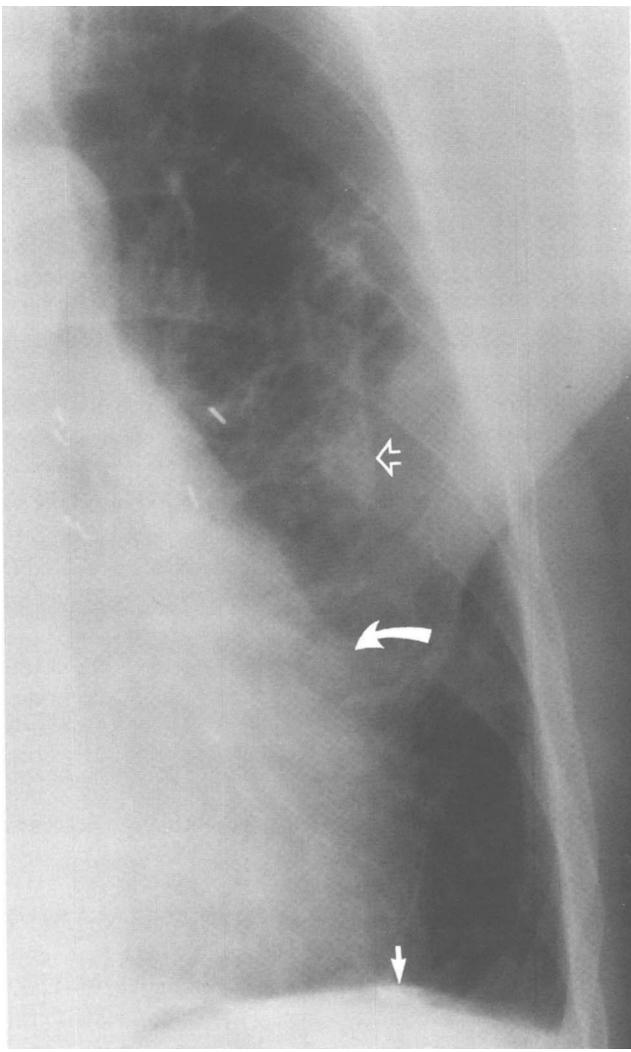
The chest x-ray film from a patient with a long history of asbestos exposure demonstrates calcified diaphragmatic pleural calcification (solid white arrow), parietal pleural plaques (open white arrow) and blurring of the left heart border ("shaggy heart sign") due to the pleural plaques and underlying fibrosis (curve white arrow).
